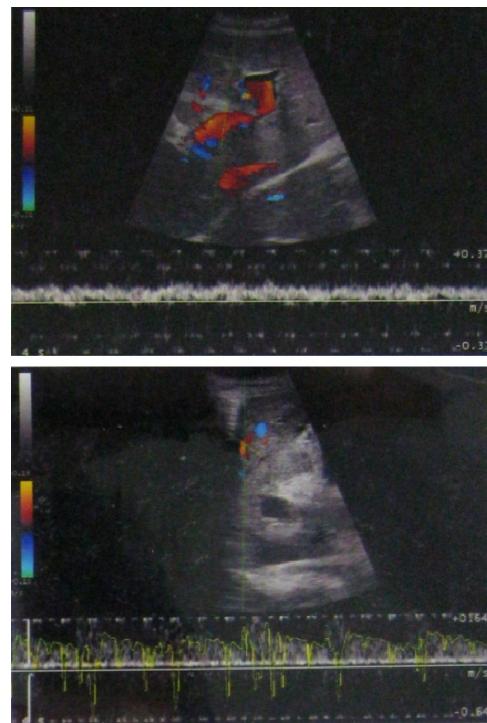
Vascular doppler ultrasound showed dilatation of portal and hepatic vein
